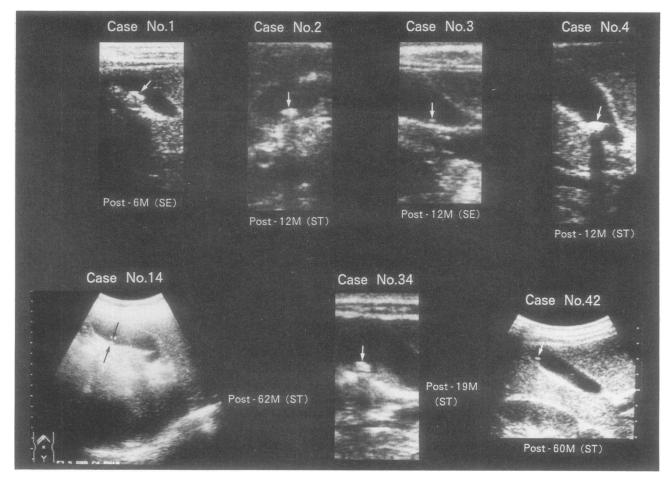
Ultrasonographic observation of gallstones induced after gastrectomy. SE, strong echo without acoustic shadow; ST, strong echo with acoustic shadow; W, week; M, month.
